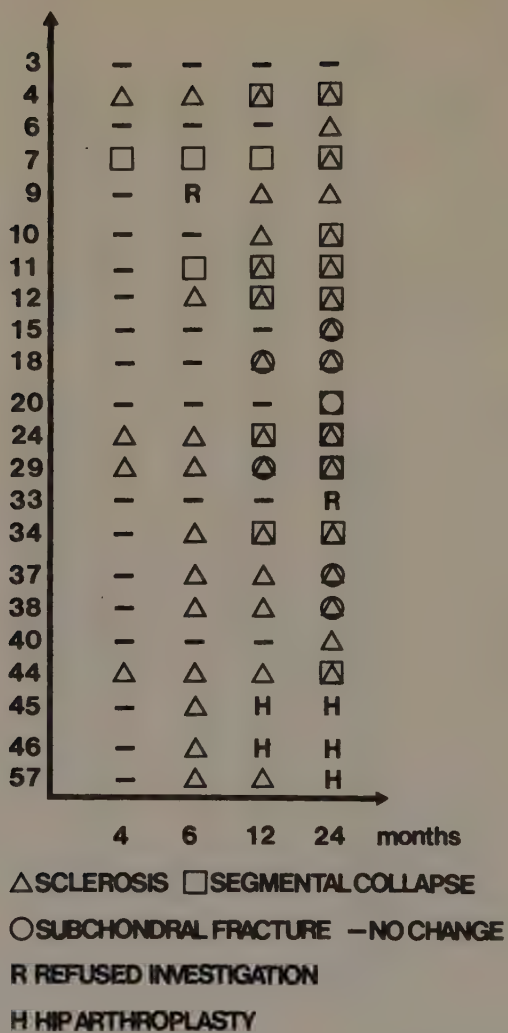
Radiographic changes in the femoral head in 22 necrosis cases
